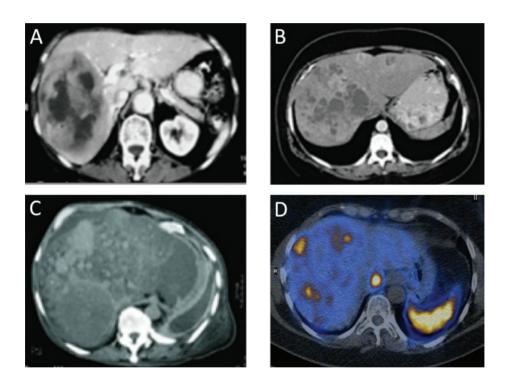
Three different patterns of liver metastases are recognized: Type A (A), Type B (B) and Type (C). Metastatic lesion seen in PET/CT (D). (Images with permission of John Wiley and Sons).
